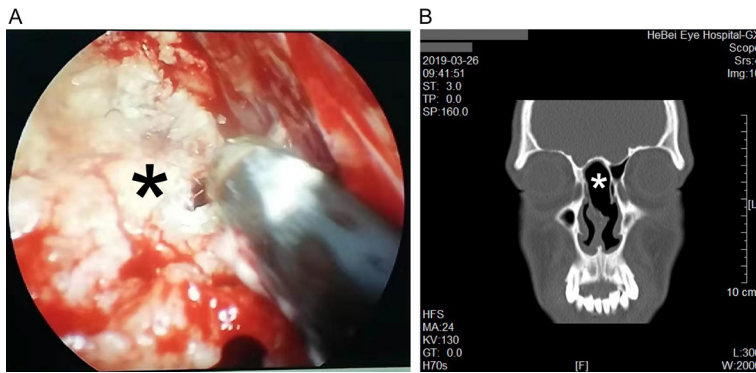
Intraoperative endoscopic findings and postoperative coronal CT imaging. A. Intraoperative endoscopic view after opening of the septal cyst cavity. The asterisk indicates exposed keratinous and sebaceous debris, mixed with hair shafts, which is characteristic of a dermoid cyst. B. Postoperative coronal CT image obtained two weeks after surgery. The asterisk marks a patent surgical fenestration on the left side of the nasal septum, communicating with the nasal cavity, consistent with successful marsupialization.
